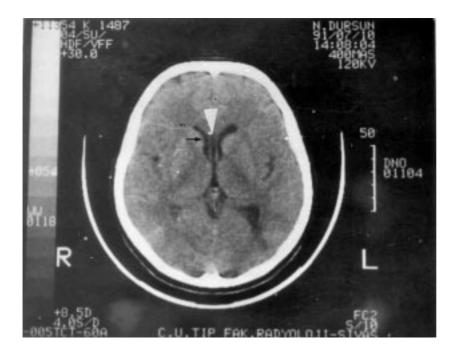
Axial brain computed tomographic scan showing CSP. (white arrow-CSP, arrow-lateral ventricle).
